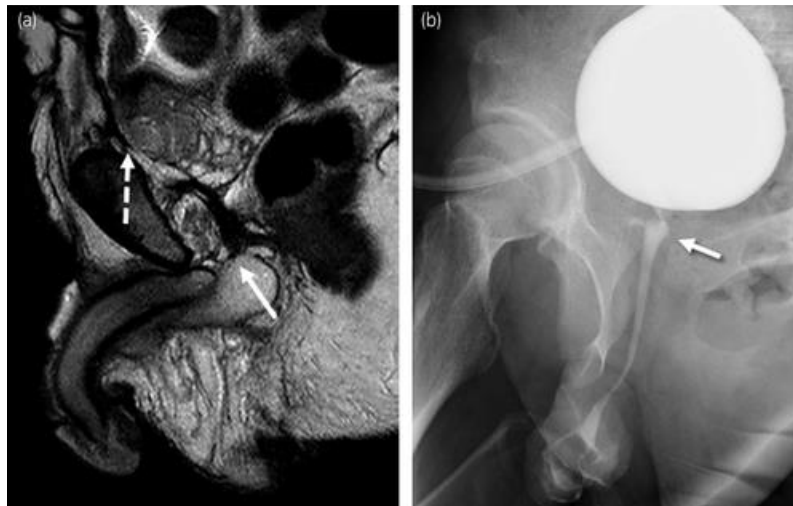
A case of severe PFUI with secondarily developed long urethral stenosis requiring an abdominoperineal approach. (a) Preoperative sagittal T2-weighted MRI showed a long urethral gap. Arrow indicates the distal urethral end and dotted arrow indicates the proximal urethral end. (b) Postoperative voiding cystourethrography. Arrow indicates the anastomotic site.
